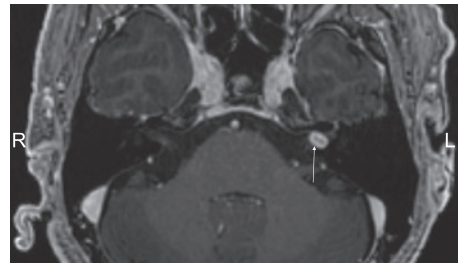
Brain magnetic resonance imaging (MRI). T1-weighted contrast-enhanced MRI reveals a 0.7-cm enhancing mass in the left internal auditory canal (arrow).
